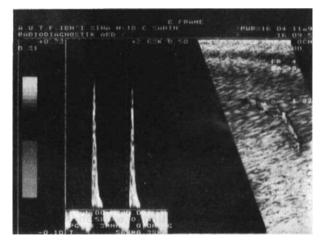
Color flow sonogram of a man with normal erections. Longitudinal color Doppler sonogram shows left cavernosal artery with angle-corrected cursor placement.
